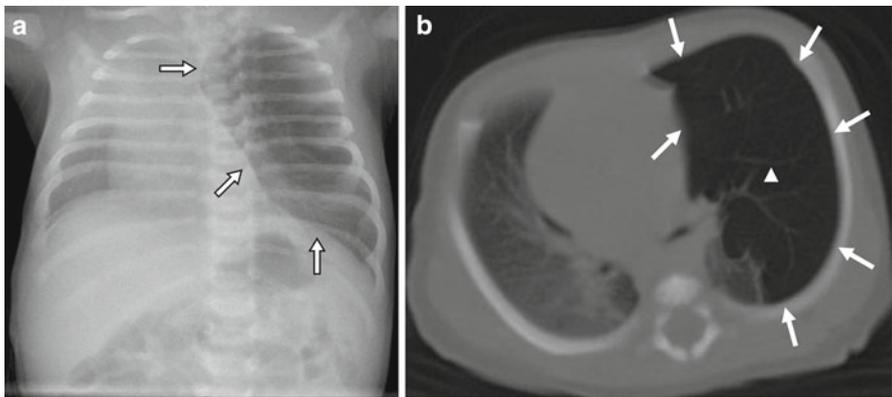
Congenital lobar overinflation. (a) Chest radiograph shows a left upper lobe lucency (*arrows*) with mediastinal shift to the contralateral side and compressive right lung atelectasis. (b) Axial CT image in the same patient. Marked hyperinflation of the left upper lobe (*arrows*) with significant mediastinal shift and right lung atelectasis. Note that the vascularity (*arrowhead*) in the affected lobe is attenuated
